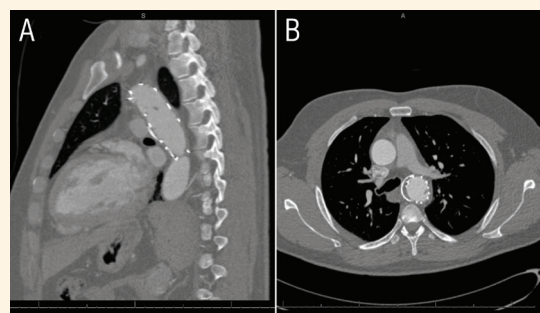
A linear intra-stent thrombus in a 37-year-old male patient seen on computed tomography angiography after thoracic endovascular aortic repair.
